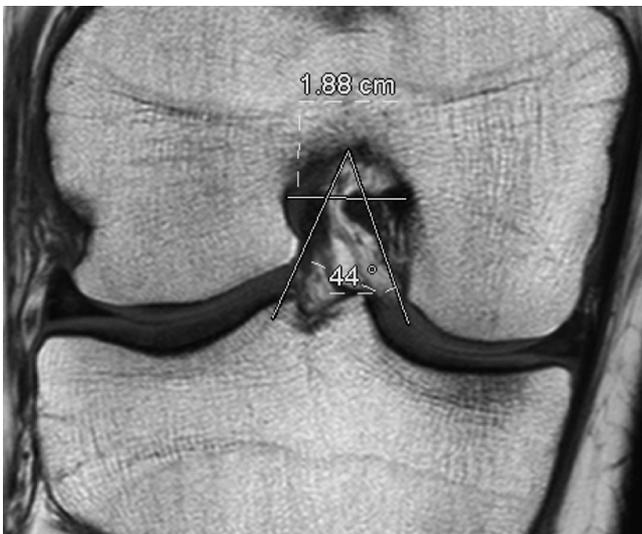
T1-weighted coronal magnetic resonance image of a right knee showing acceptable values of intercondylar notch width but unacceptably low values of notch angle.
